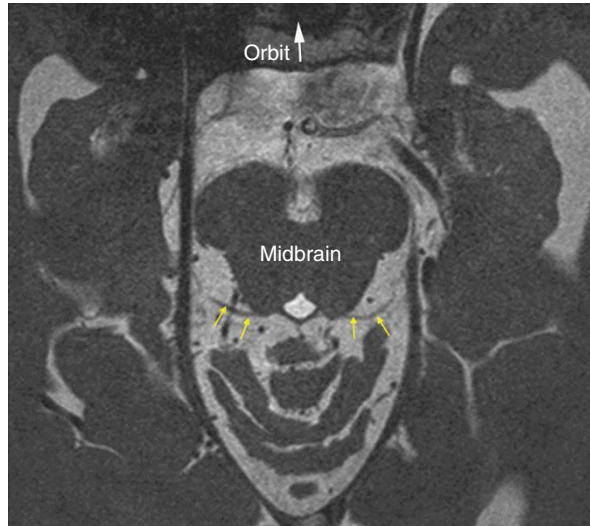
High-resolution MRI showing the right and left trochlear nerves (yellow arrow) arising from the dorsal midbrain. Courtesy of Jae Hyoung Kim, M.D., Department of Radiology, Seoul National University Bundang Hospital, South Korea.
